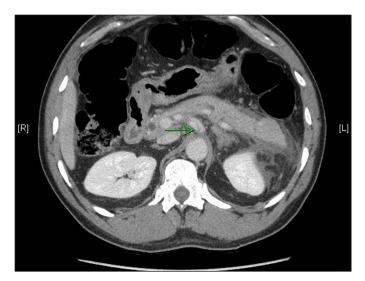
CT abdomen/pelvis showing dissection originating at celiac trunk origin.
